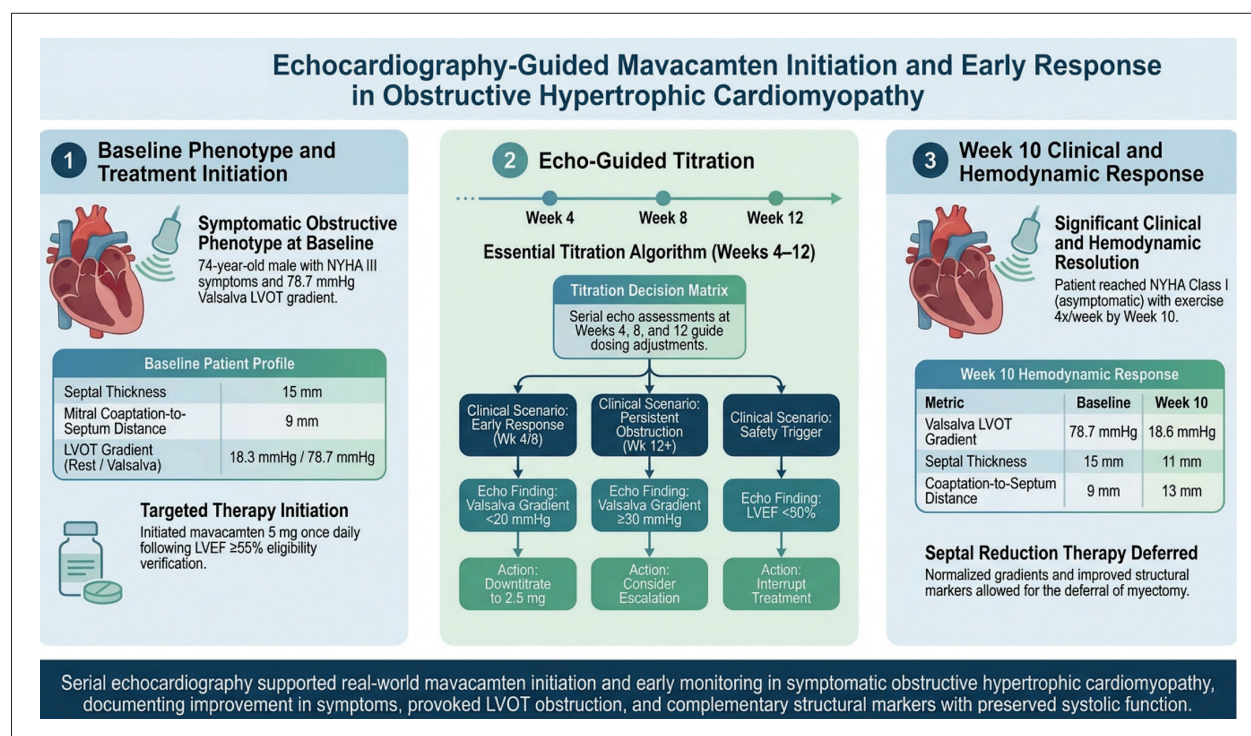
Echocardiography-guided initiation and early dose adjustment of mavacamten in a patient with symptomatic obstructive HCM, showing improved symptoms, reduced provoked LVOT gradient, and increased mitral leaflet–septal distance with preserved left ventricular systolic function. LVEF: left ventricular ejection fraction.
